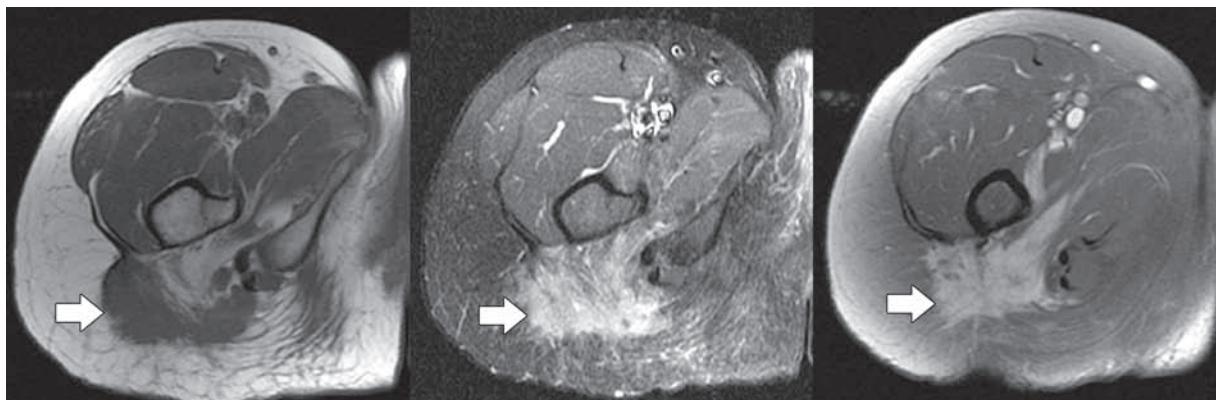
Fibromatosis. Left: Axial T1-weighted MR image shows a lesion (arrow) in the proximal right thigh. The lesion is isointense relative to muscle. Middle: On a T2-weighted fat-saturated MR image, the lesion (arrow) has variable signal intensity, which depends on its cellularity. Right: Gadolinium-enhanced T1-weighted fat-saturated MR image shows enhancement of the lesion (arrow).
